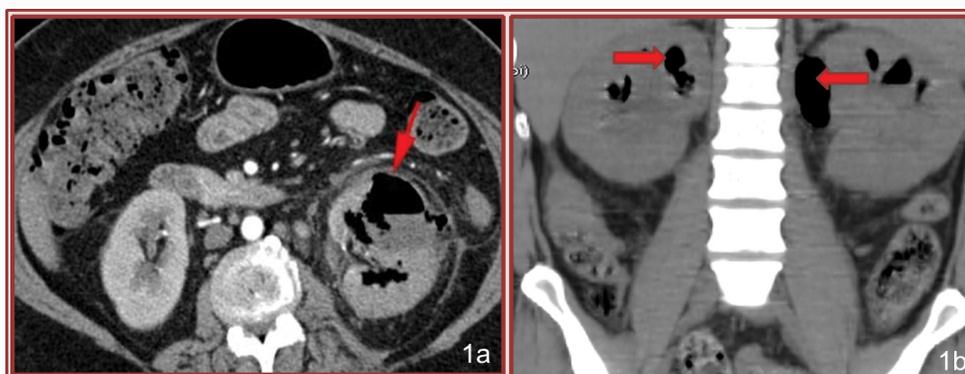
CT findings of EPN.
